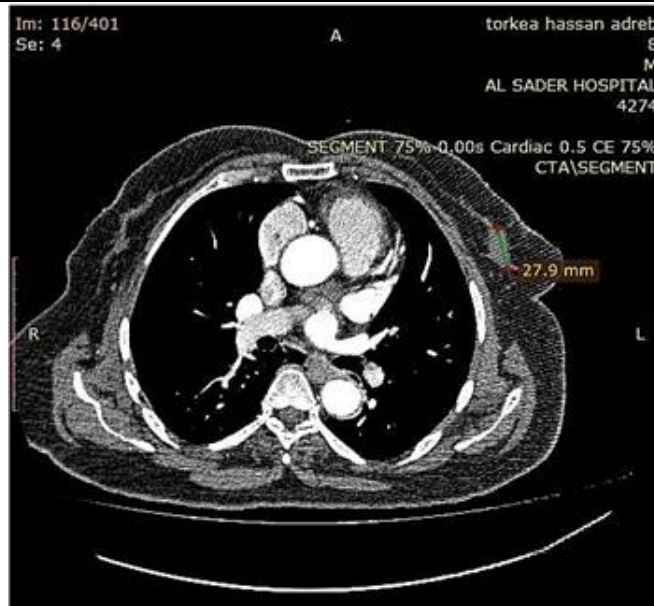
Breast mass incidentally detected in 40 -year-old woman who was referred for coronary CT angiography for chest pain.
